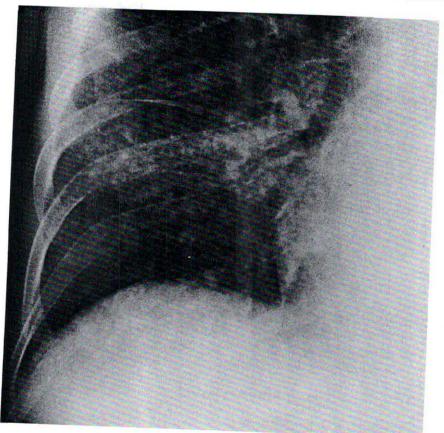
Portion of chest radiograph showing nodular lesions in a patient with disseminated tuberculosis.
